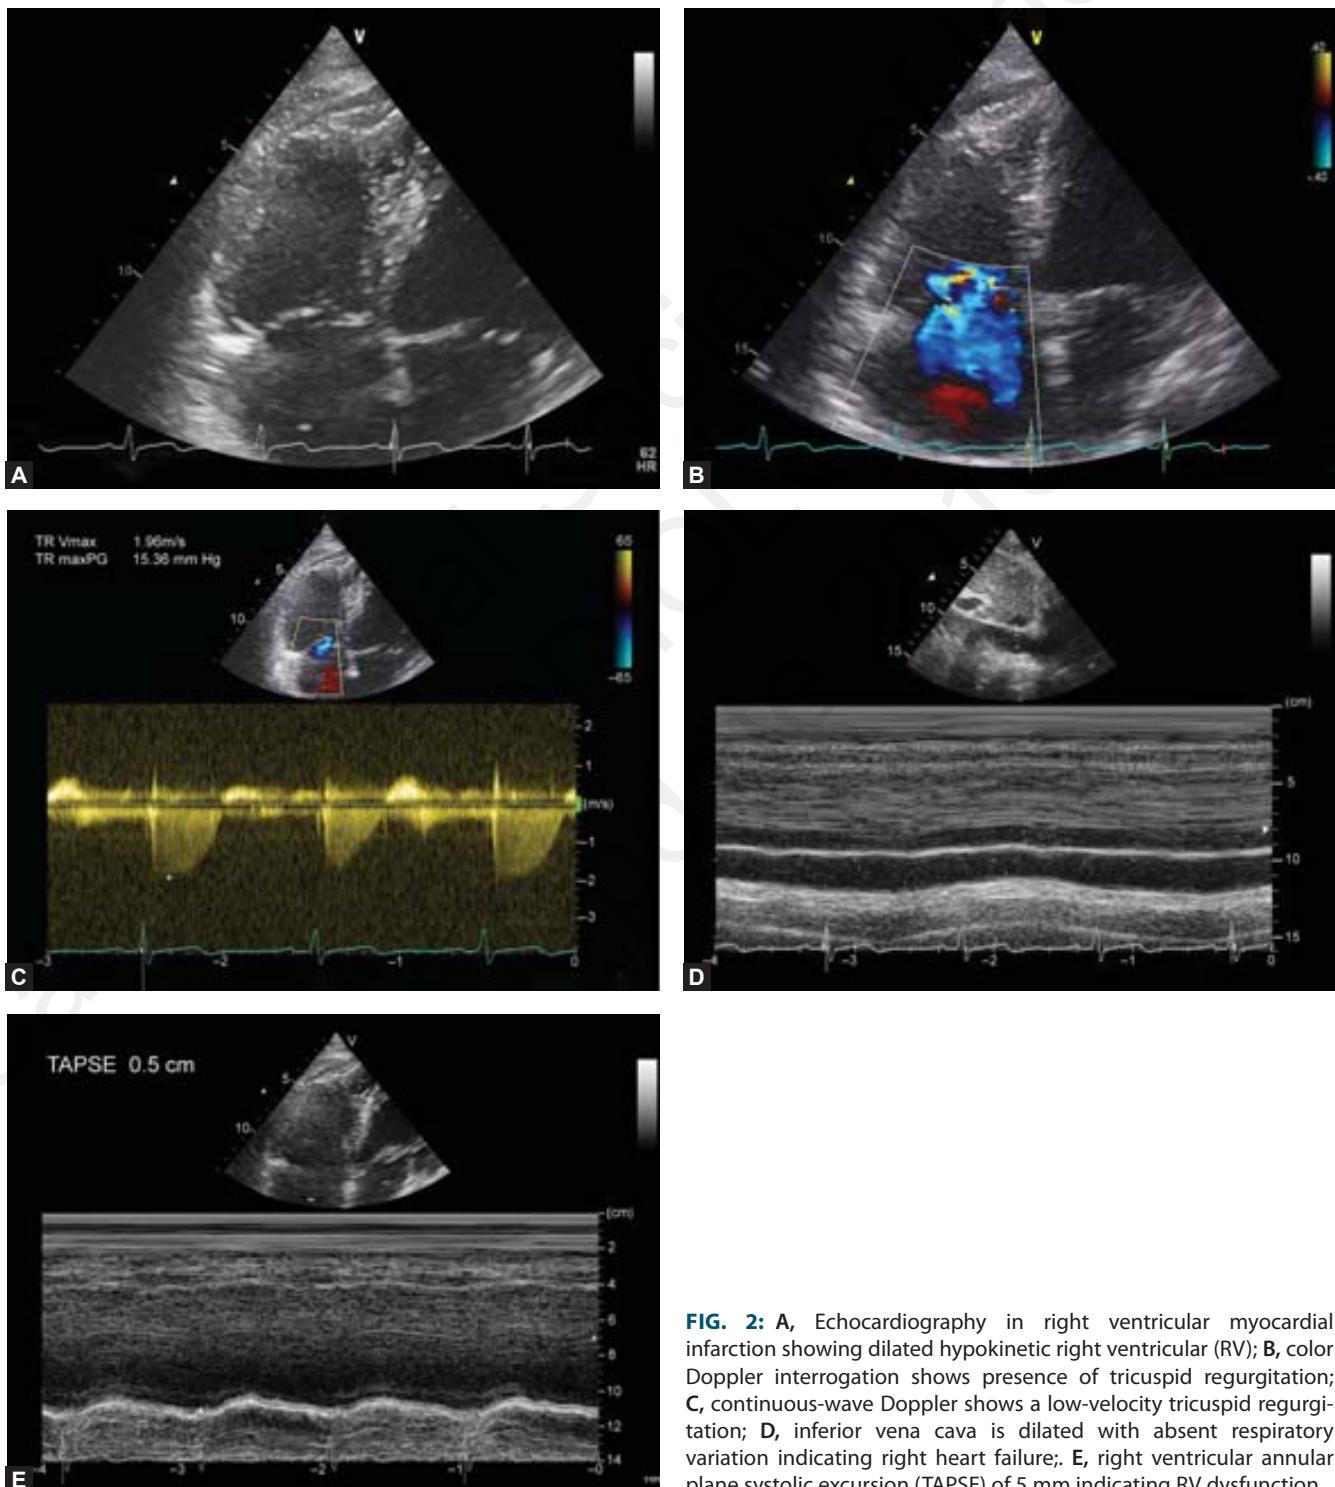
A, Echocardiography in right ventricular myocardial infarction showing dilated hypokinetic right ventricular (RV); B, color Doppler interrogation shows presence of tricuspid regurgitation; C, continuous-wave Doppler shows a low-velocity tricuspid regurgitation; D, inferior vena cava is dilated with absent respiratory variation indicating right heart failure; E, right ventricular annular plane systolic excursion (TAPSE) of 5 mm indicating RV dysfunction.
